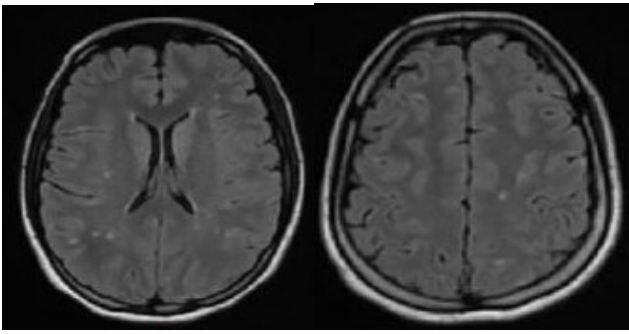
MRI of the head Contrast axial section of T2 Flair sequence
